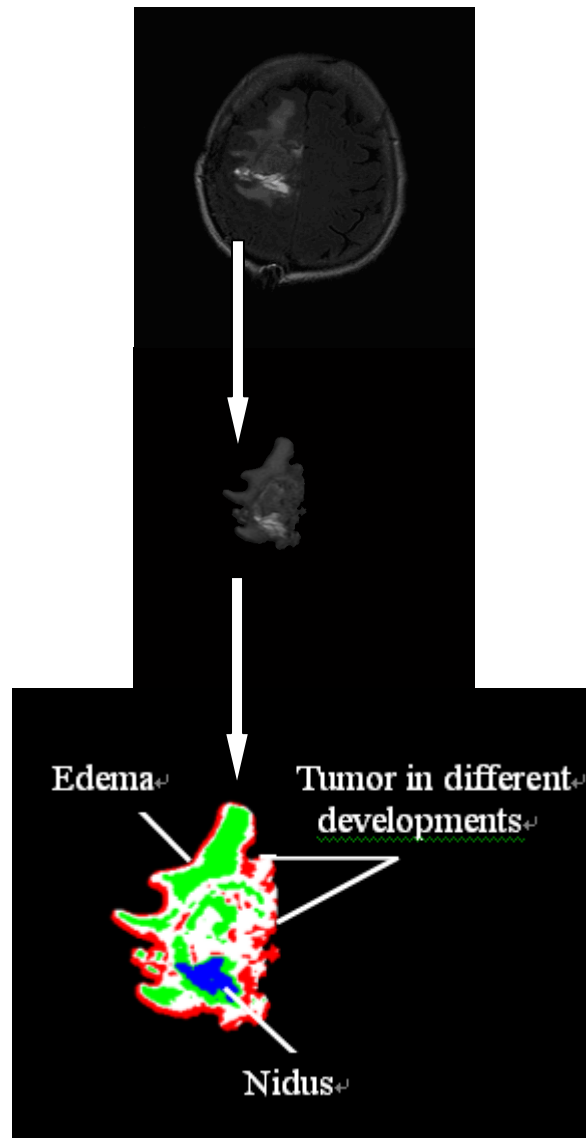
Tissue classification in Patient 2 (FLAIR images)
